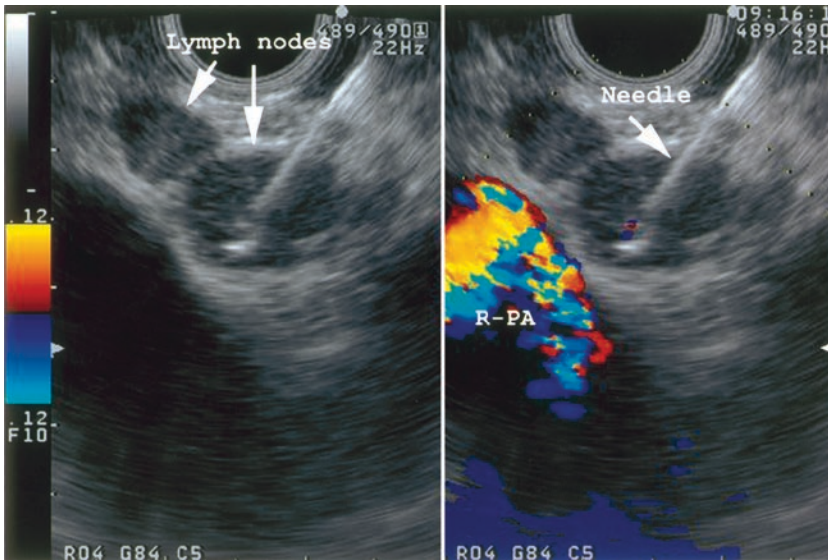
The left image is a fundamental ultrasound image and the right image is the simultaneous image with Color Doppler function. The needle was inserted into a mediastinal
